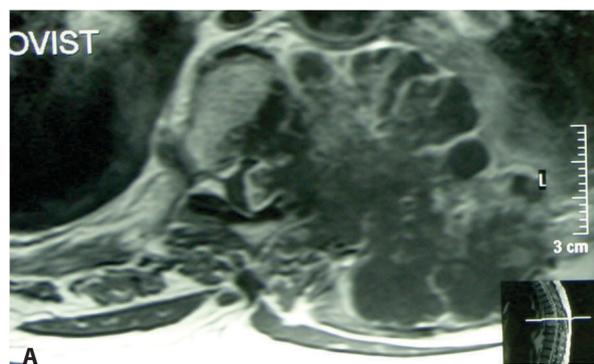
Preoperative MRI of a Patient with Chondrosarcoma of 6th and 7th Segments of the Thoracic Spine. A: Axial View. B: Coronal View.
